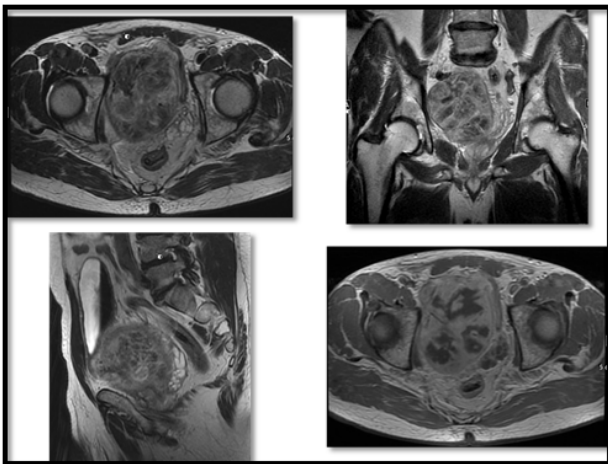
MRI of Prostate sarcoma
